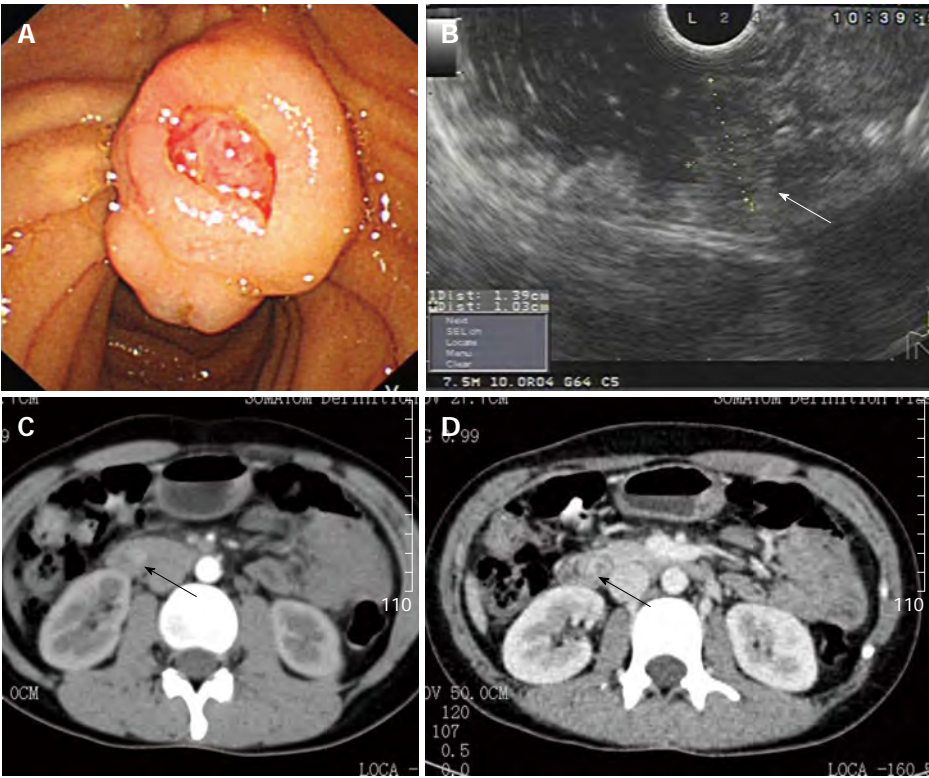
Periapillary tumor (arrow) was detected by gastroscopy, endoscopic ultrasonography, and computed tomography. A: Gastroscopy; B: Endoscopic ultrasonography; C, D: Computed tomography.
